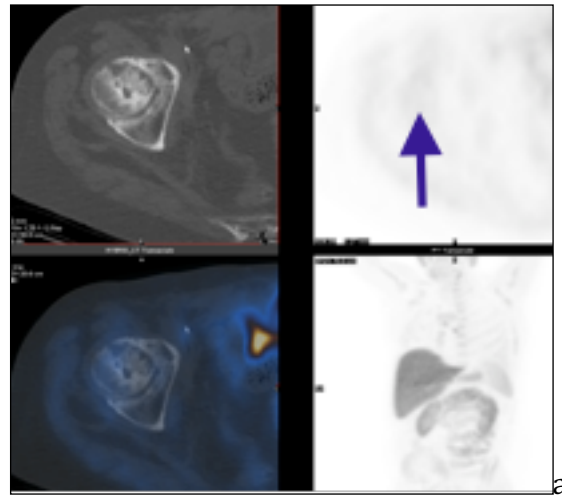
a ^{18}F -FECH PET/CT (multiplanar) demonstrating a very faintly avid area at the right femoral head with cystic appearances. b The coronal MRI scan demonstrates a focal area of low signal involving the right femoral head with loss of height. This patient had a previous history of avascular necrosis of the right femoral head.
